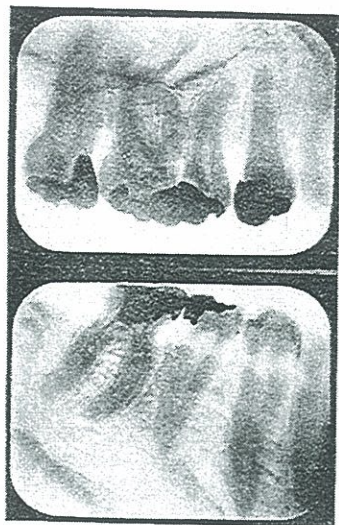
ROENTGENOGRAPHIC APPEARANCE OF TEETH OF CASE 1224, THE CULTURE FROM WHICH PRODUCED THE OVARIAN CYST SHOWN IN FIGURE 300. THE PATIENT HAD RECENTLY BEEN OPERATED FOR REMOVAL OF LARGE OVARIAN CYST.
